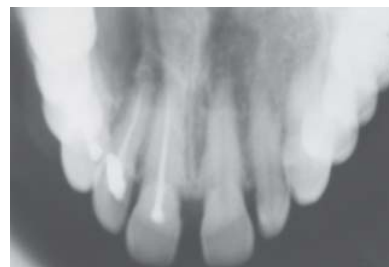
An occlusal radiograph showing well defined radiolucency at the periapical area of left maxillary central incisors
